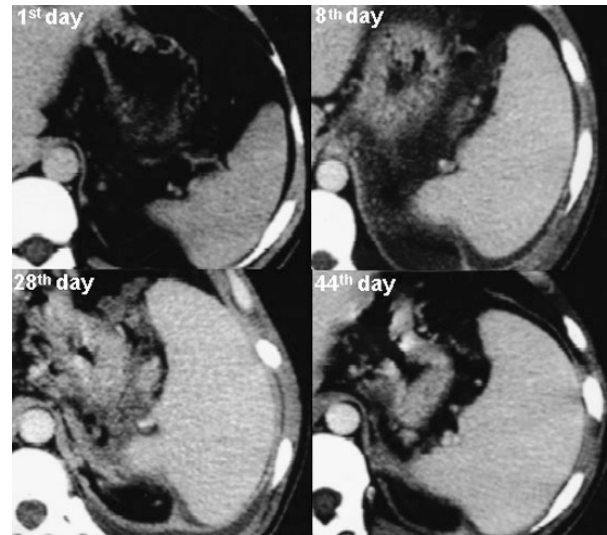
Multidetector computed tomography scan: spleen involvement.
